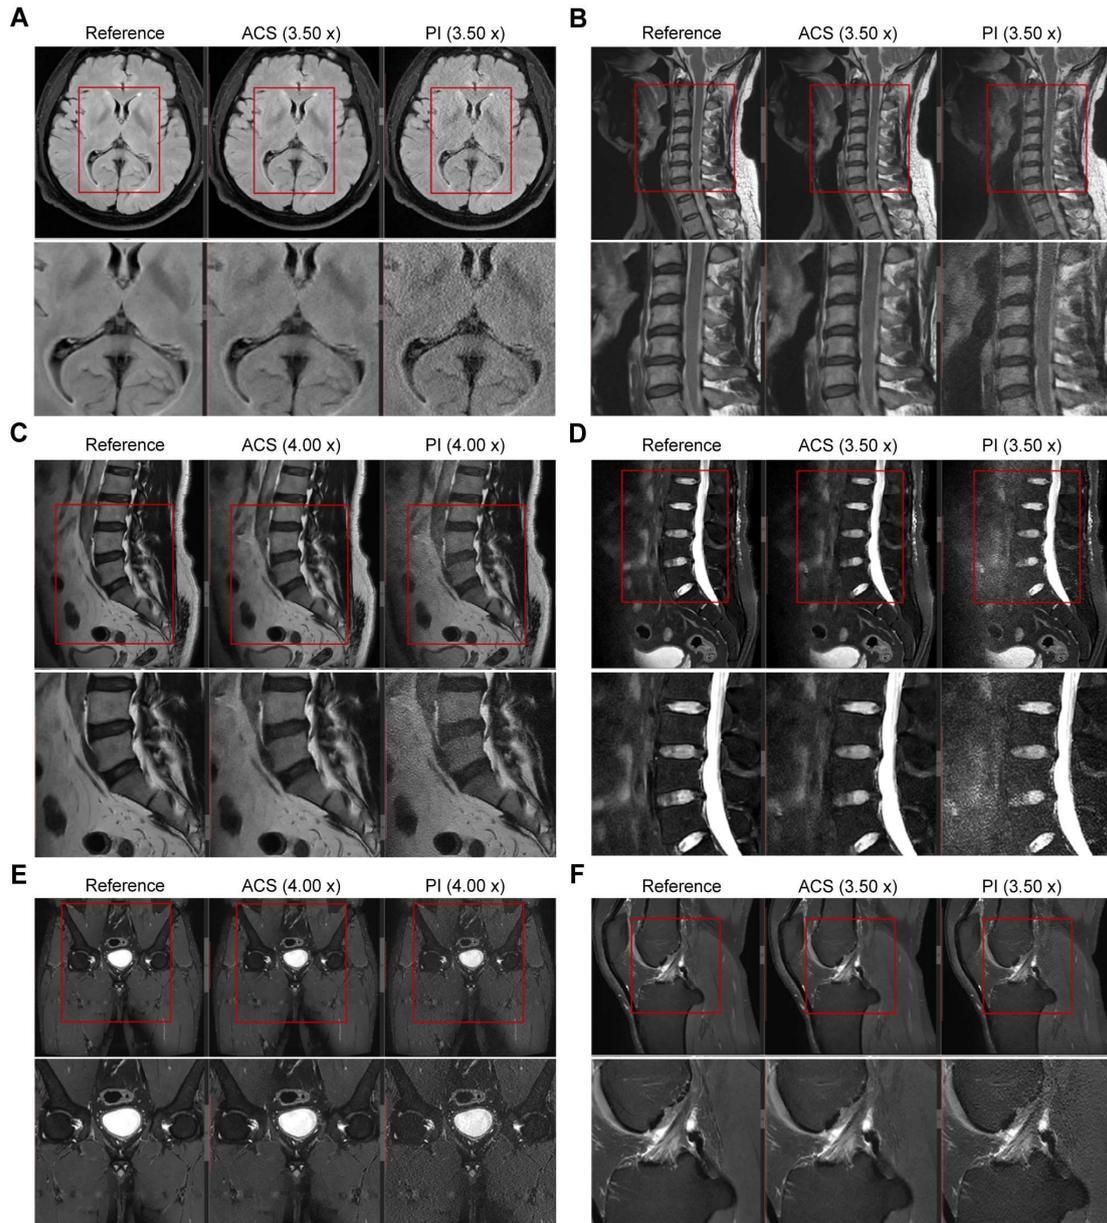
Comparison between ACS and PI reconstructions of down-sampled MRI data collected from various organs using multiple pulse sequences in the testing dataset. Related to Figure 2. (A) T2w FLAIR images of the head ($3.50 \times$ acceleration). (B) T2w images of the cervical spine ($3.50 \times$ acceleration). (C) T2w images of the lumbar spine ($4.00 \times$ acceleration). (D) T2w fat reduction images of the lumbar spine ($3.50 \times$ acceleration). (E) STIR images of the hip ($4.00 \times$ acceleration). (F) PDw fat reduction images of the knee ($3.50 \times$ acceleration).
